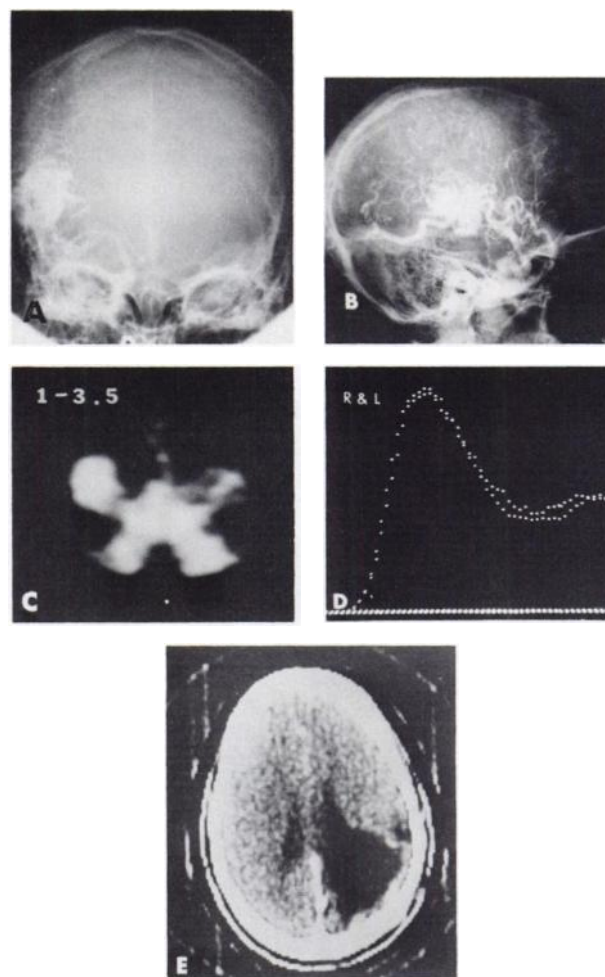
Nineteen-year-old girl (Patient 1) with AVM arising from right middle cerebral artery (RMCA). A-P cerebral angiogram (A) shows AVM fed by RMCA. Lateral angiograms (B) show AVM draining anteriorly and posteriorly but not into superior sagittal sinus. Anterior dynamic study (C) shows AVM associated with RMCA while cerebral hemispheric curves (D), show tracer distribution surprisingly similar. CT scan (E) after contrast injection disclosed porencephaly (explaining the curves) but failed to show the AVM.
